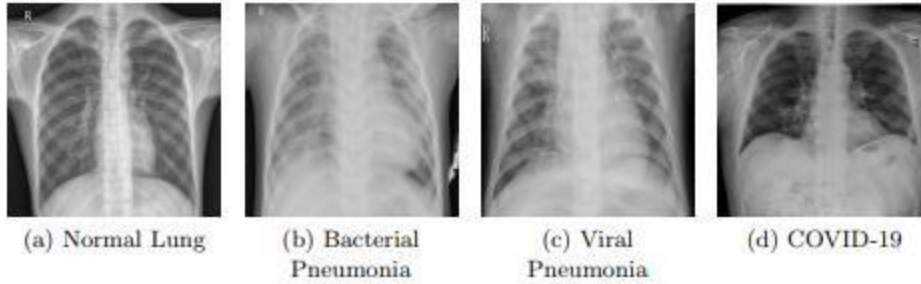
Class-wise examples of frontal-view chest X-Ray images. The patient with bacterial pneumonia shows consolidation of the right lower lobe. Radiograph of a patient with viral pneumonia shows patchy consolidation in the right middle and lower zone. The last image from a patient with COVID pneumonia shows patchy ground glass opacity in the Left Lower Zone labels $y_c \in \{0, 1\}$, indicating absence or presence of class c symptoms in the image respectively. We use the weighted binary cross-entropy loss as suggested by CheXNet [7]:
